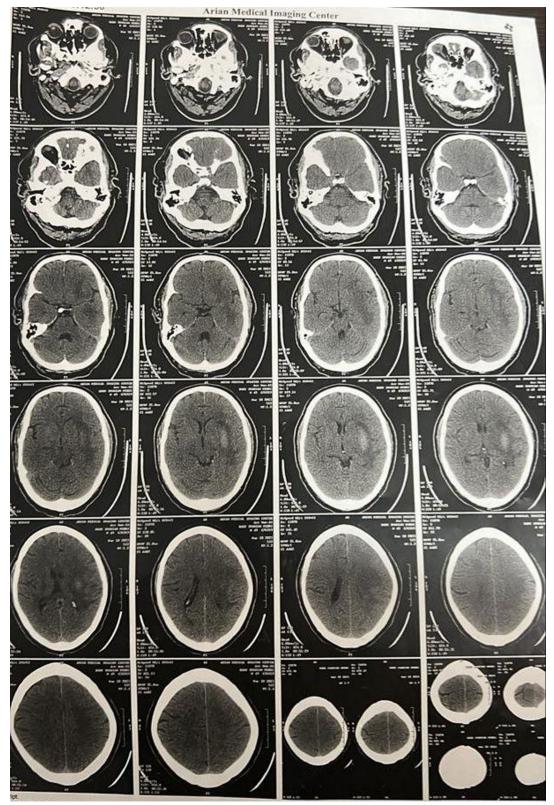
Computed tomography scan of the patient at the onset of the stroke
